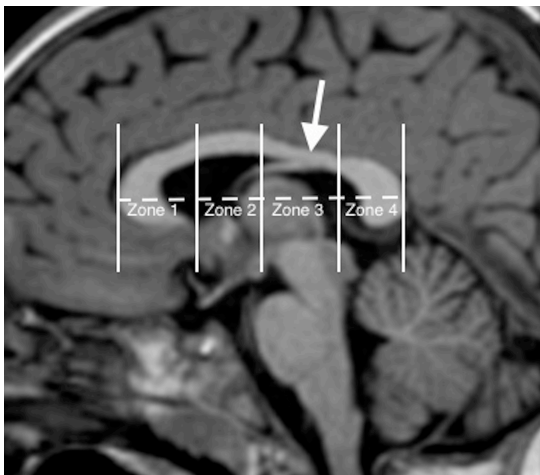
Midline T1 sagittal MRI scan in a 5-year-old girl with transverse myelitis the fornix can be seen inserting into zone 4 (arrow)
